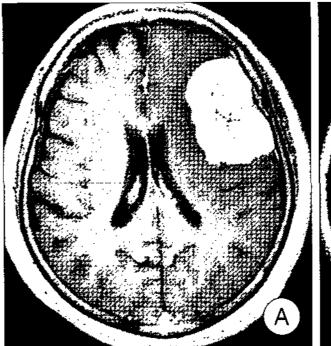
A : Axial T2-weighted magnetic resonance (MR) image demonstrating a homogeneously iso-intensity mass approximately 4.5cm in diameter with peritumoral edema. B : Axial T1-weighted gadolium-enhanced MR image demonstrating a homogeneously well-enhancing mass with broad base in dura of left frontal convexity.
